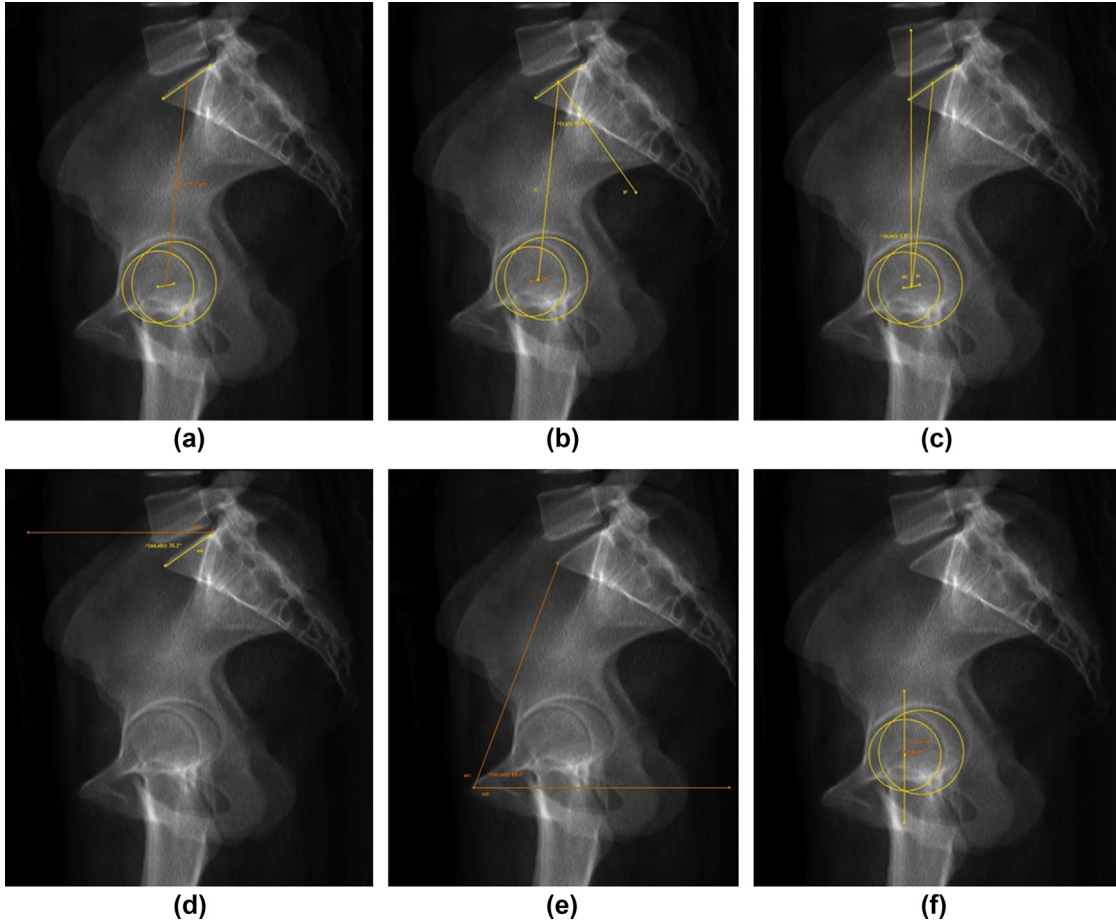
Representation of the measured pelvic parameters on lateral radiographs using the SterEOS 2D toolbox: (a) sagittal pelvic thickness, (b) pelvic incidence, (c) pelvic tilt, (d) sacral slope, (e) pelvic inclination, (f) bifemoral distance.
